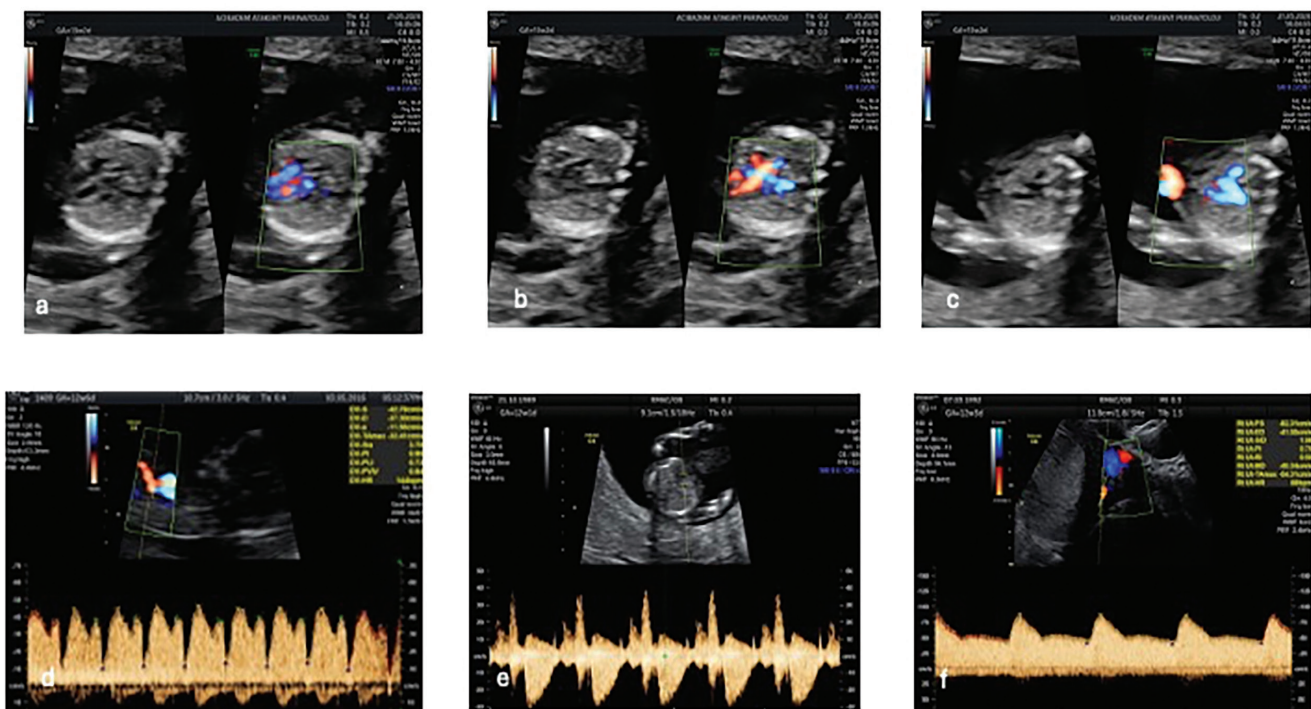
Standard sonographic planes for heart exam and Doppler exam in the first-trimester exam (with high definition flow Doppler). 4-chamber view (a), crossing of great vessels (b), three-vessel view (c), triphasic flow of Ductus venosus (d), assessment of tricuspid valve regurgitation (e), uterine artery Doppler (f)
